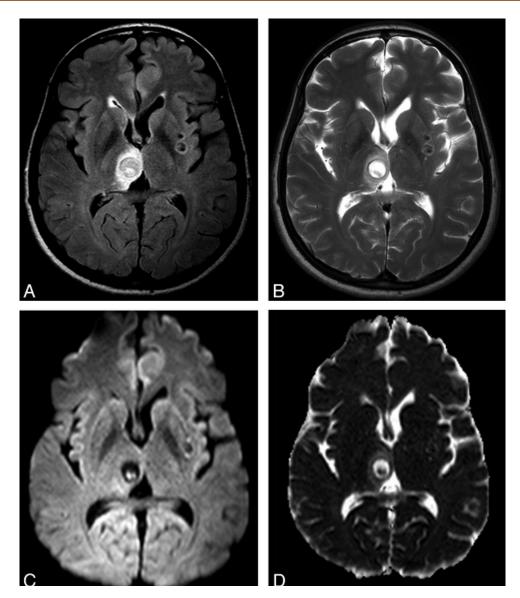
MR images demonstrating restricted diffusion in scolex in a case of NCC^{97}
